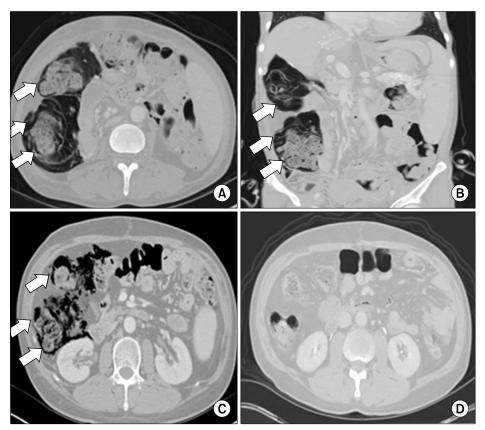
Imaging of the case 1 and 2: Computed tomography (CT) scans of case 1 patient revealed pneumatosis intestinalis (PI) (white arrows) involving the right ascending colon on an axial image (A) and a coronal image (B). CT scans of case 2 patient revealed PI (white arrows) involving the right ascending colon (C), which was spontaneously resolved after 3 weeks (D).
